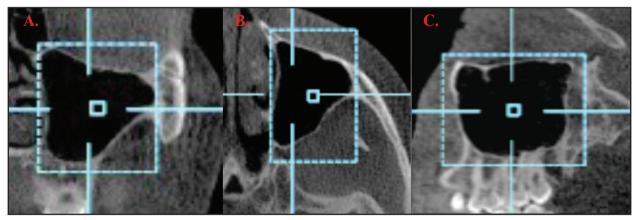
Cone beam CT; Magnification of outlined and selected Maxillary sinus. A. Coronal view. B. Axial view. C. Sagittal view
